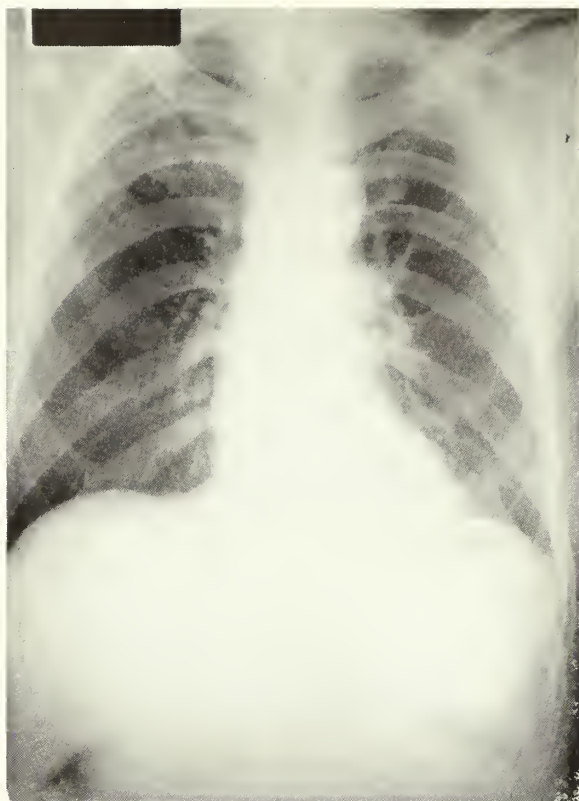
Admission PA chest x-ray.
